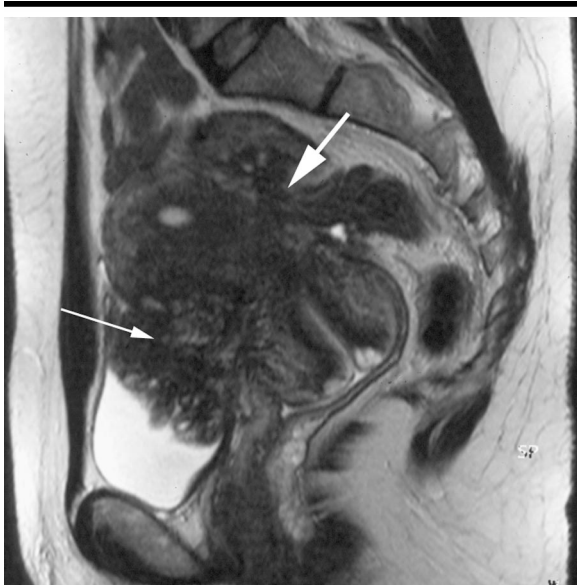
Sagittal T2-weighted fast spin-echo MR image (4,500/128) demonstrates large fibrotic area that protrudes into lumen, related to invasion of mucosal layer, and that forms a vesicouterine block of tissue with associated diffuse anterior endometriosis (thin arrow). Complete obstruction of vesicouterine pouch and rectal wall involvement (thick arrow) are present. True-positive diagnosis of bladder endometriosis was determined at MR imaging.
